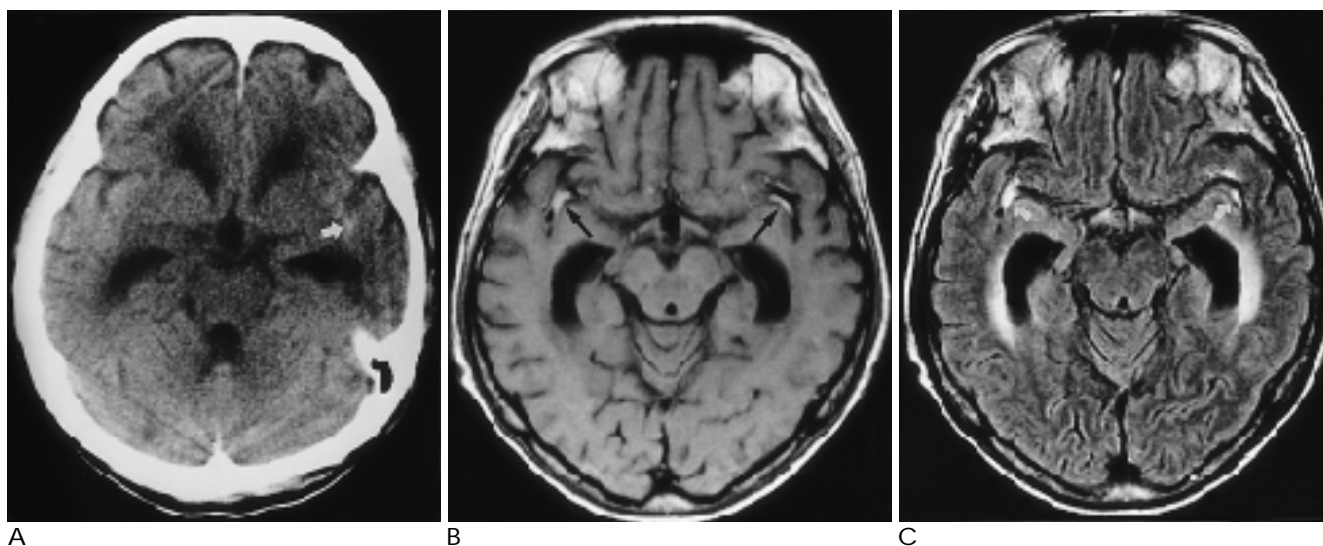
Chronic subarachnoid hemorrhage in 66-year-old woman with unknown cause. Unenhanced CT scan was obtained 3 weeks after ictus. T1-weighted and FLAIR MR images were obtained 4 weeks after ictus.
